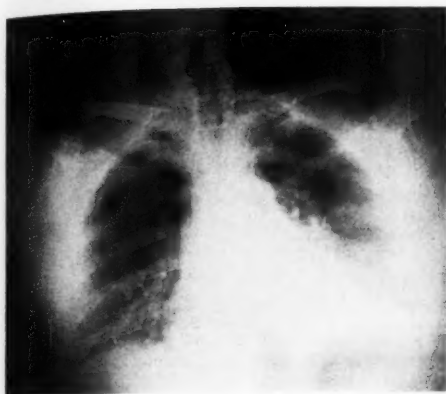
Case III. Roentgenogram of the chest, showing bilateral pulmonary infiltrates, left hydrothorax, mediastinal emphysema, and subcutaneous emphysema.
